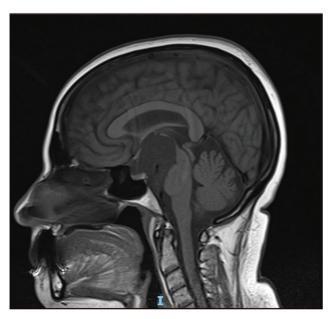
Enterogenous cyst: MRI exhibiting a cystic lesion near the suprasellar cistern.
